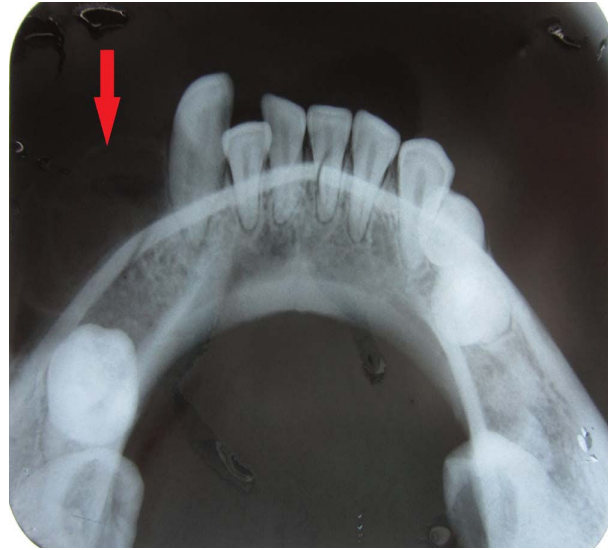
Mandibular occlusal radiograph showing soft tissue shadow
